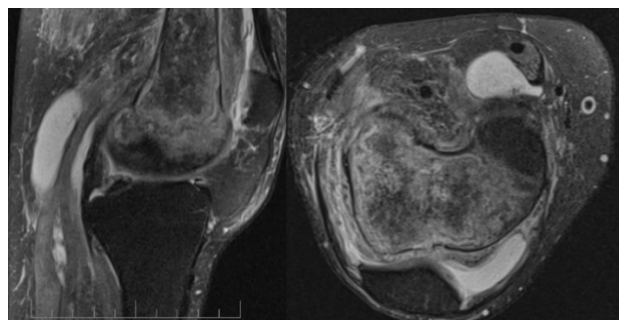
MRI images of the knee
